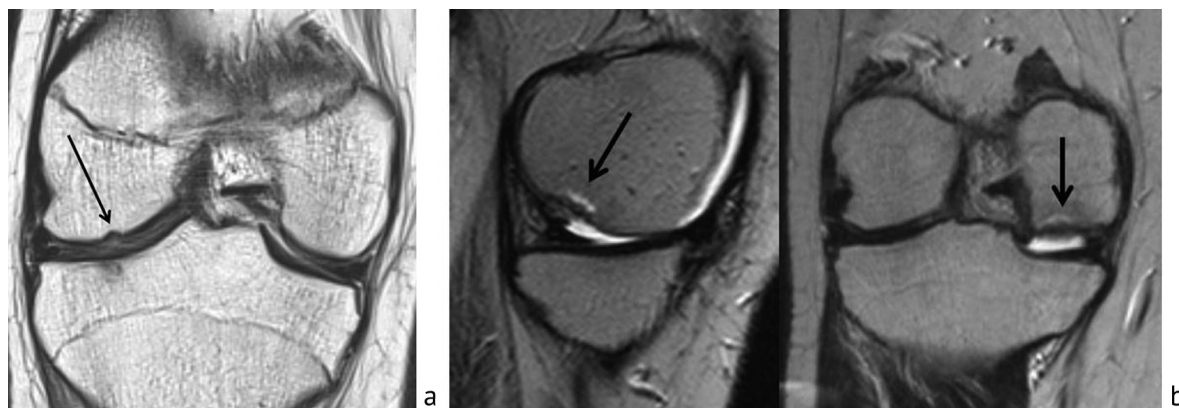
Pathology of the femoral condyles revealed by MRI: *a* defect of the articular surface (arrow), corresponding to Fig. 1, *a*; *b* defect of the articular surface (arrow), corresponding to Fig. 1, *b*
